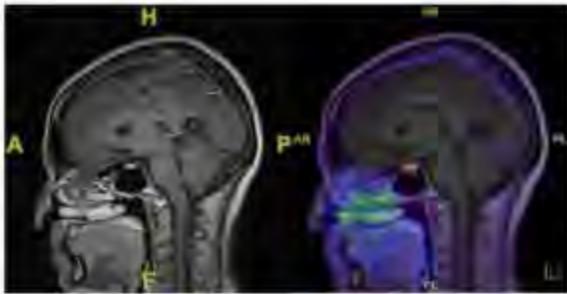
Sagittal T1 post contrast MRI of the brain (left) and fused DOTATATE PET/MR (right) demonstrating avid DOTATATE uptake in the sella turcica.
